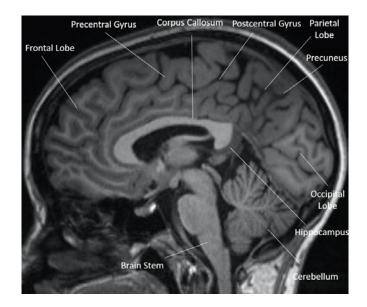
Sagittal View of the Brain Including the Location of Key Areas Within the Brain. Source: Gateway MRI Center, Joint School of Nanoscience and Nanoengineering, The University of North Carolina at Greensboro.
